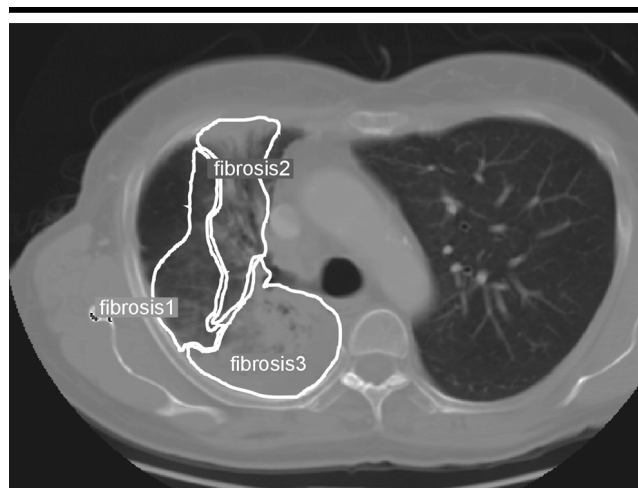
Transverse CT section shows typical fibrosis volumes.
